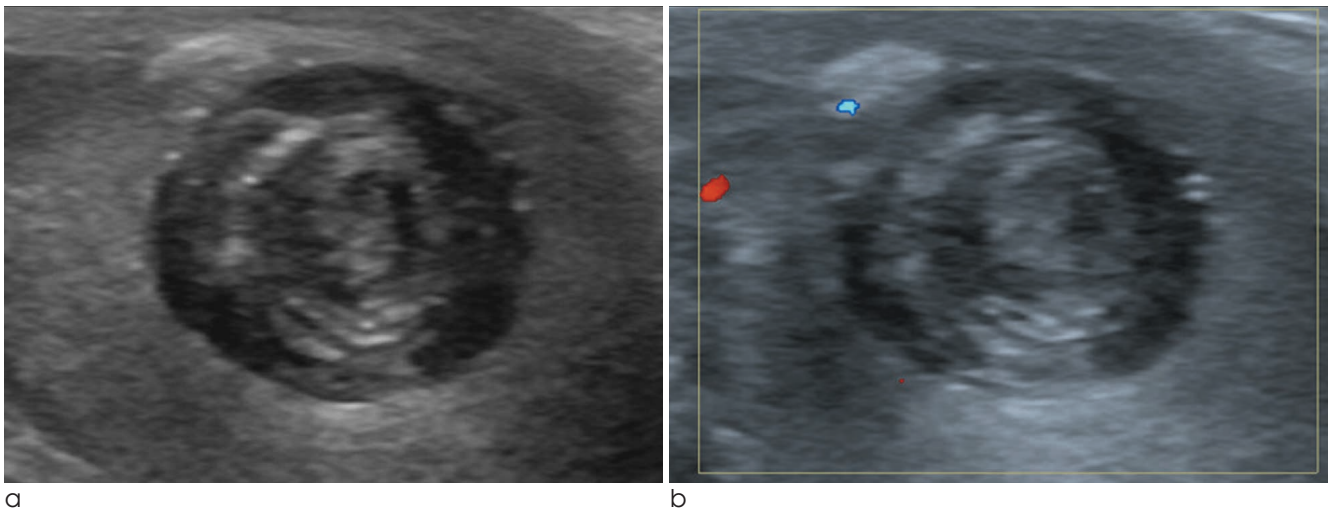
Ultrasonography (US) finding for the testicular epidermoid cyst. (a) Gray scale transverse US reveals a well-circumscribed intratesticular mass in the mid portion of right testis. It shows alternating rings of hyper- and hypoechogenicities. (b) Doppler US reveals no vascularity in the mass.
